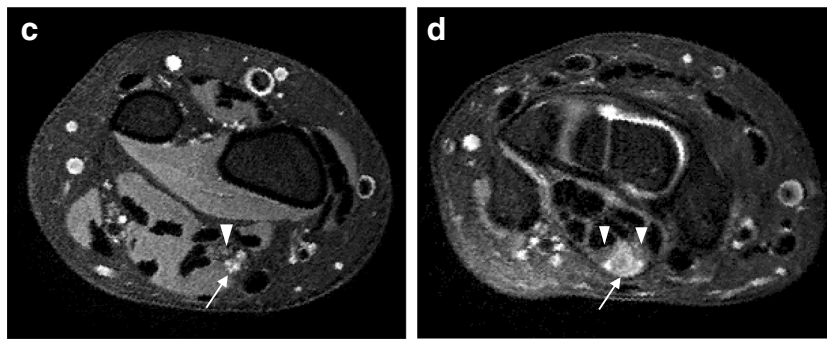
c Axial fat-suppressed PDW FSE MR image of the right distal forearm shows the persistent median artery and venae comitantes (arrow) adjacent to the median nerve (arrowhead) just proximal to the carpus. d
